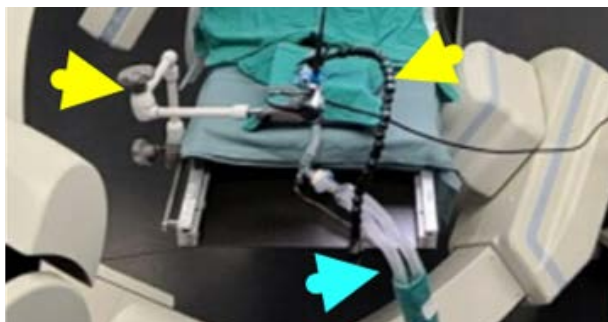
Bronchoscope holders (yellow arrowheads) attached to tableside rails used during CBCT. (Left) Neuwave Medical; (Right) GoPro camera holder. Ventilator tubes (blue arrowhead) are run straight from patient's head to avoid collision with C-arm.
